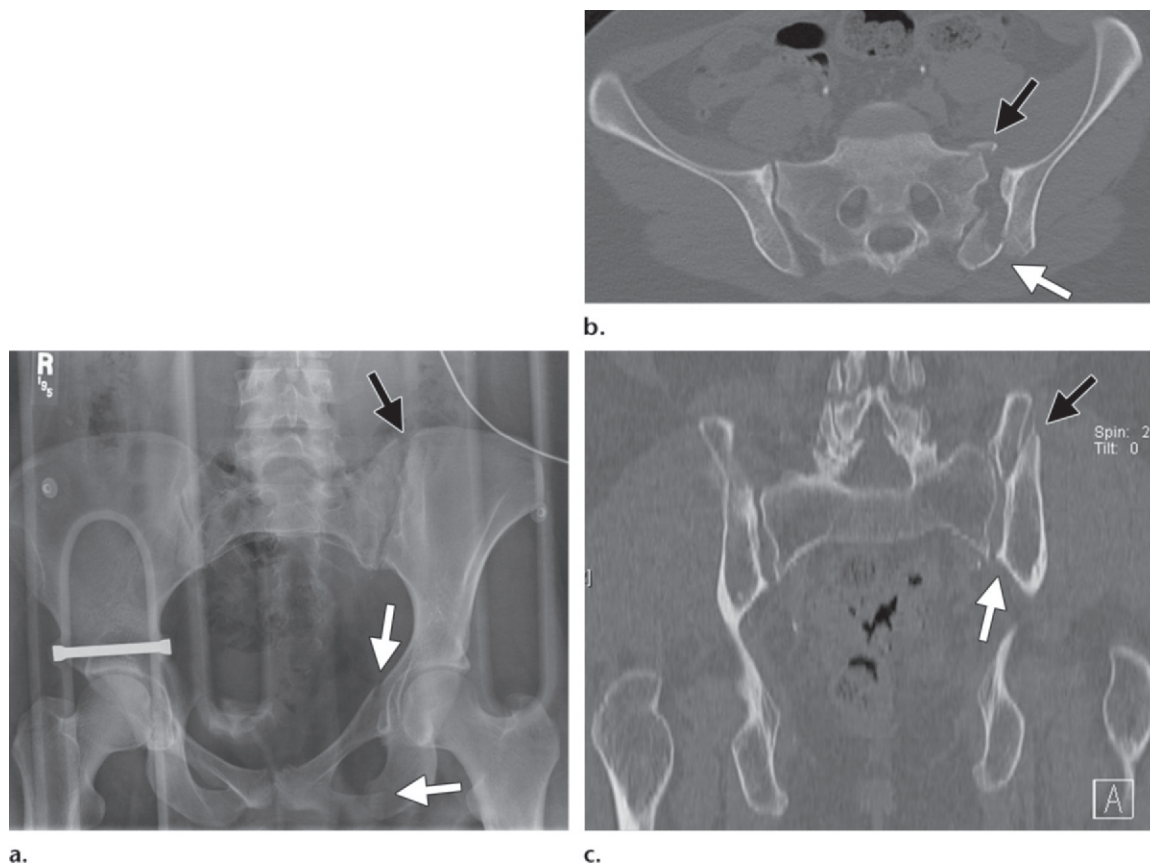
Lateral compression type 2 injury in an 18-year-old woman who was an unrestrained driver in a motor vehicle accident. (a) Pelvic radiograph shows left-sided overlapping superior and inferior pubic rami fractures (white arrows) and widening of the left SI joint (black arrow). (b) Axial CT image shows a fracture of the anterior sacrum at the site of the anterior SI ligament attachment (black arrow) and widening of the SI joint. A crescent fracture (white arrow) involving the left iliac bone is also seen. The posterior SI ligament is keeping the fragment attached to the sacrum. (c) Coronal CT image obtained at the level of the posterior SI joint shows the crescent fracture (black arrow). No craniocaudal displacement of the iliac bone (white arrow) is seen, a finding that excludes vertical shear injury. The patient underwent open reduction and internal fixation of the left SI joint.
